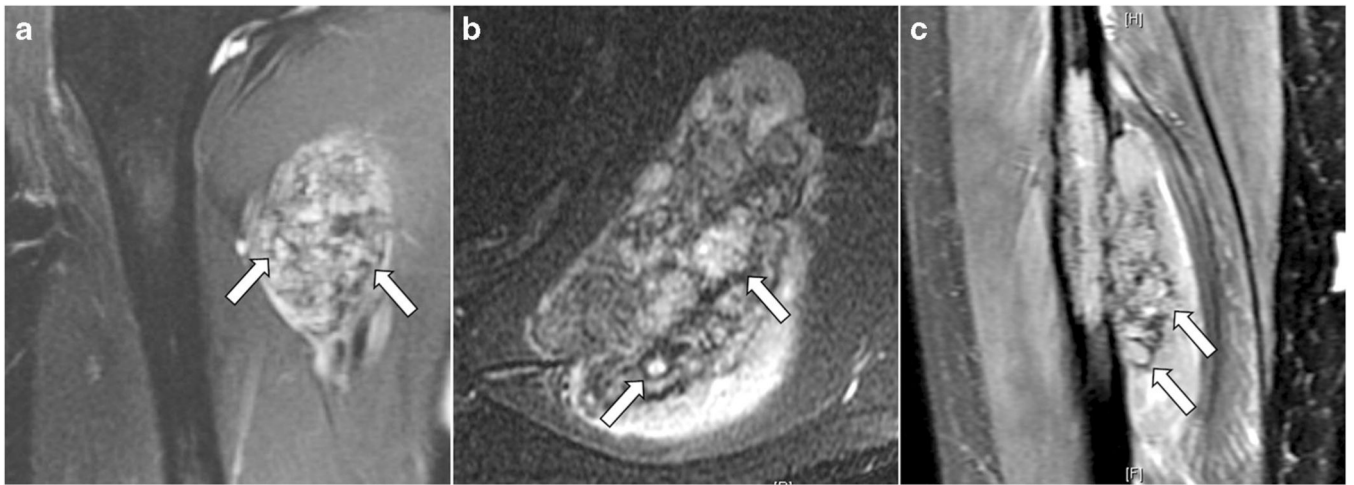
Three examples of “chondroid matrix” on fat-suppressed T2-weighted MRI depicted by the presence of T2-hyperintense lobules (arrows) surrounded by peripheral T2-hypointense signal in a case of extraskeletal mesenchymal chondrosarcoma in the upper medial thigh (a), a primary skeletal lesion in the scapular body (b), and another primary skeletal lesion in the mid-diaphysis of the fibula (c)
